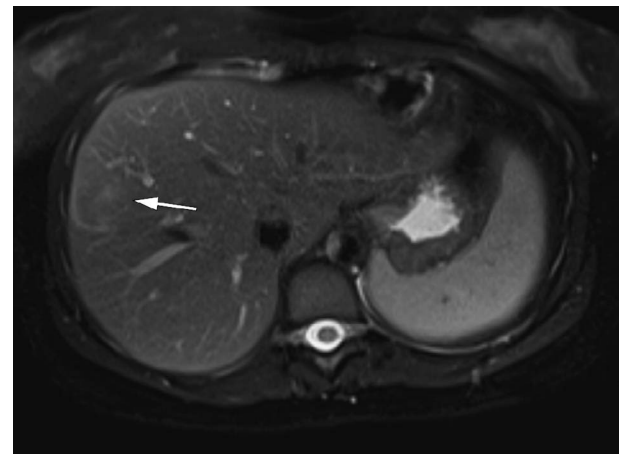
FNH. Annotated. Liver. MRI. T2 weighted. Single shot. Fat suppression. Axial plane. An arrow points to the right hepatic lobe mass. It is isointense to the background liver, consistent with FNH.
